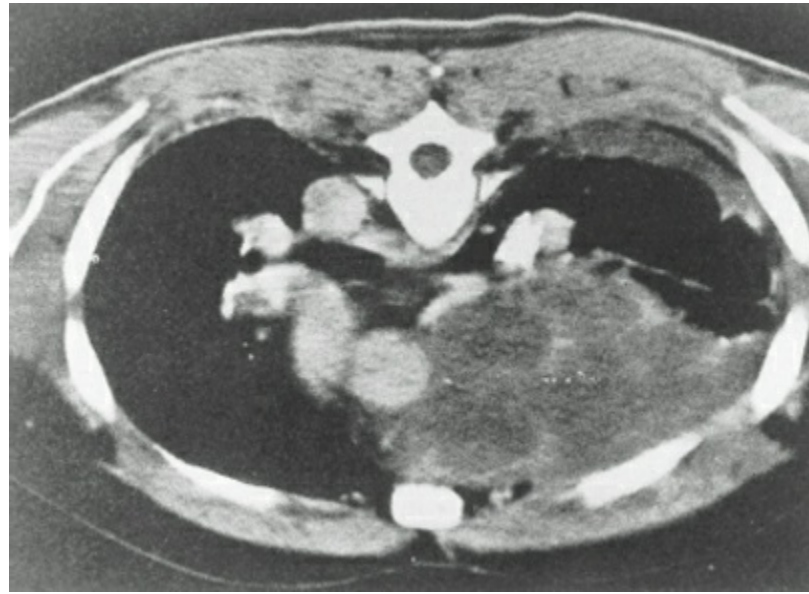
Computed tomography scan of a malignant nonseminomatous germ cell tumor of the anterior mediastinum reveals the inhomogeneous anterior mediastinal mass in contrast to the homogeneous density of a seminoma. Pleural effusion is also demonstrated in the right hemithorax. (Reproduced with permission from Shields TW. Primary lesions of the mediastinum and their investigation and treatment. In: Shields TW, ed. *General Thoracic Surgery*. Baltimore, MD: Williams & Wilkins; 1994:1724–1769.)
